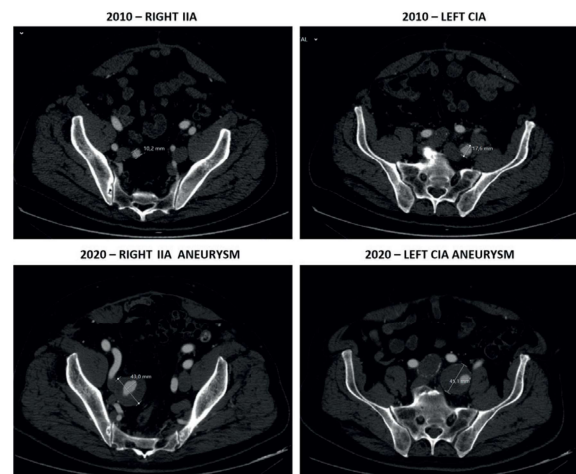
CTA showing right IIA and left CIA degeneration from 2010 to 2020.
